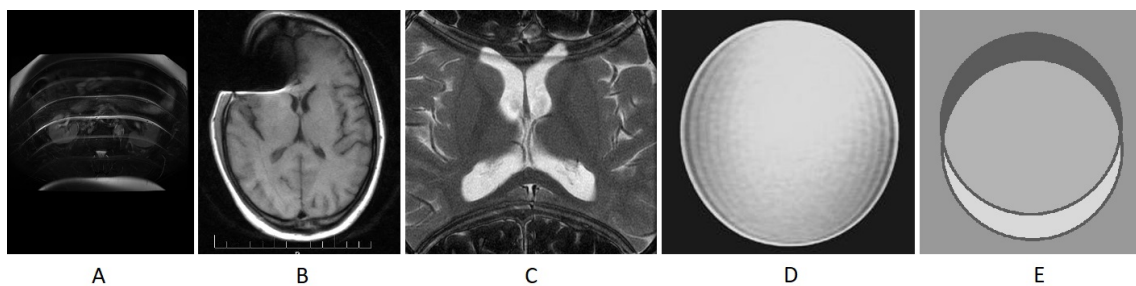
MRI common artefacts: periodic motion (A); magnetic susceptibility (B); aliasing (C); Gibb's ringing (D); chemical shift (E). Adapted from [6].*
